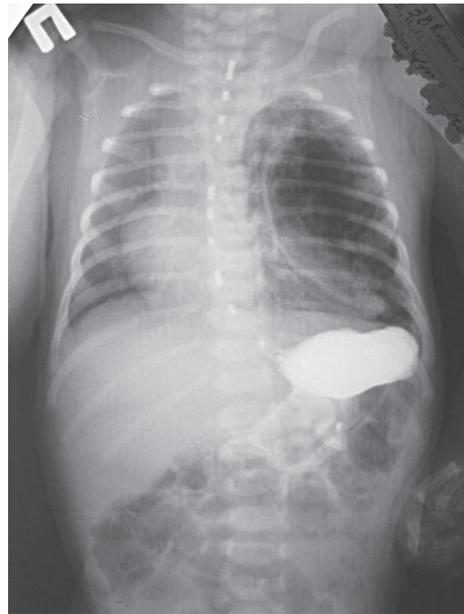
X-ray of a newborn with congenital lobar emphysema of the upper lobe of the left lung
